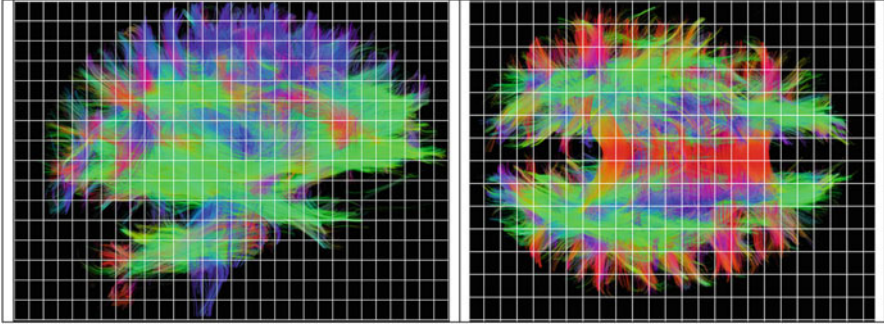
Sagittal and coronal tractographic images of a whole brain overlaid by a grid that represents a typical element size of 5 mm. Tractographic images were derived from MR images with a resolution of $1.3 \times 1.3 \times 2$ mm (courtesy of Drs. Zhifeng Kou and Ramtilak Gattu, Wayne State University)
